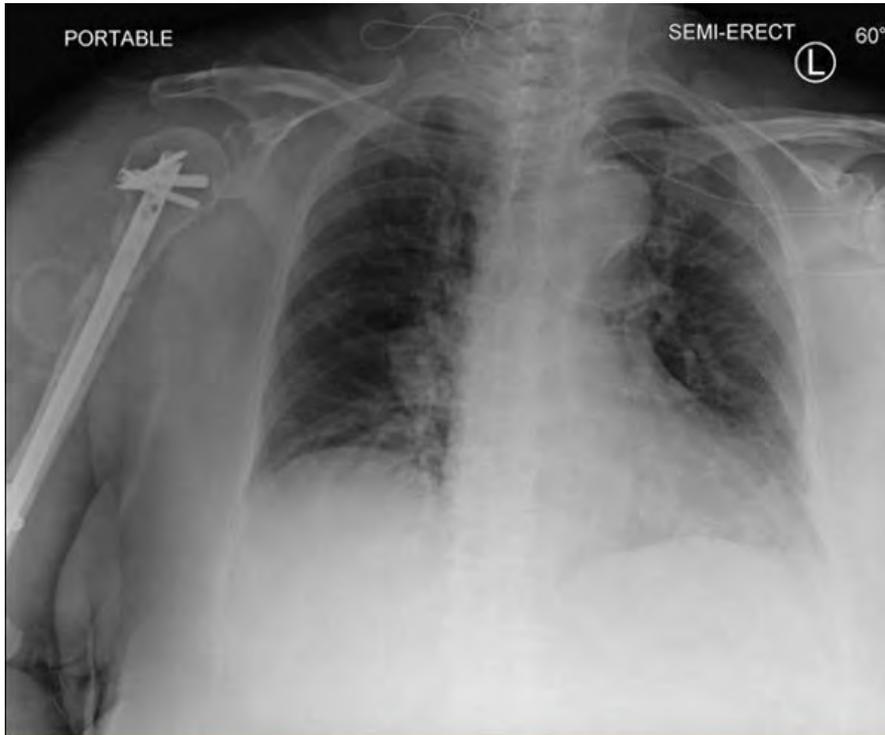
Chest radiograph on POD1.
